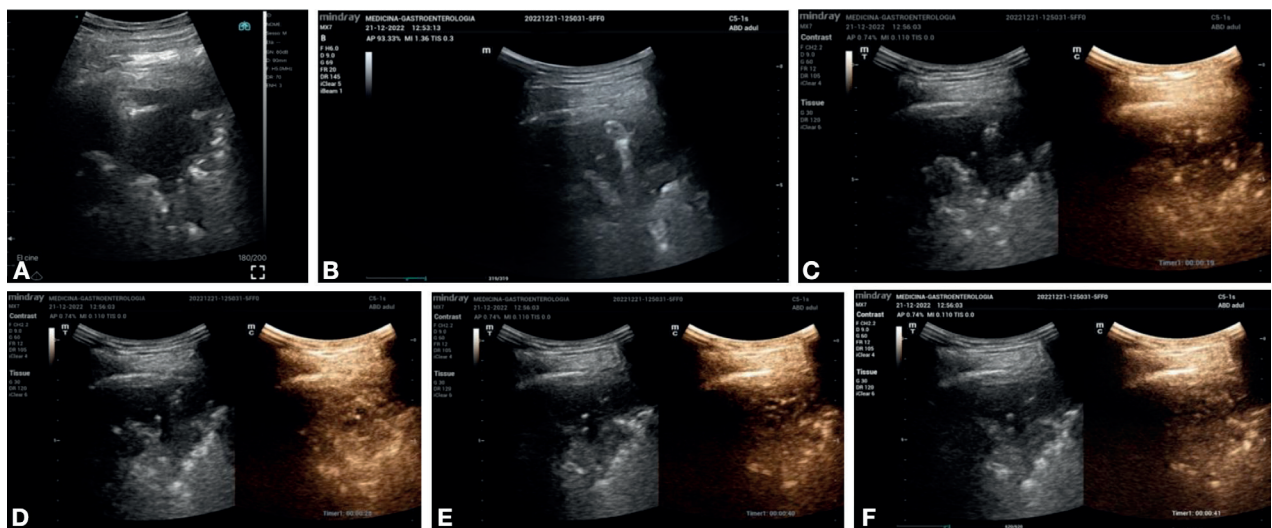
82 y old male with dyspnea and fever (with history of ischemic heart disease and smoking) CXR negative for pneumonia. Hand-held LUS demonstrated a small inhomogeneous nodule (a), negative at color-doppler examination, for which CEUS was performed at the patient's bedside; conventional ultrasound confirms the lesion (b). CEUS: arterial phase demonstrates initial enhancement after 19 seconds (c), with inhomogeneous vascularization after 28 seconds (d) and weak wash-out in portal (e) and late phase (f). CEUS diagnosis of malignant lesion; after 7 days of intravenous antibiotic therapy the lesion disappeared.
